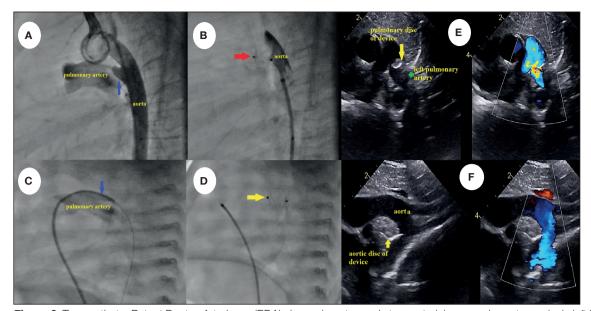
Transcatheter Patent Ductus Arteriosus (PDA) closure by retrograde transarterial approach; aortography in left lateral view shows conical type (Type-A) of PDA (A). Aortography in the left lateral view shows the implanted Amplatzer Piccolo Occluder 4/4 mm which is in the proper position within the duct and extraductal disc placement with no residual shunt and no protrusion into the aorta (B). Transcatheter PDA closure by anterograde transvenous approach and only by femoral vein access; a straight lateral image; while manually injecting the contrast, the catheter is withdrawn and the central diameter and length of the PDA [fetal type (Type-F)] are determined (C). The left lateral view shows the implanted Amplatzer Piccolo Occluder 5/4 mm in the proper position within the duct and extra ductal disc placement (D). The control echocardiography during the procedure revealed that the device did not protrude into the descending aorta or pulmonary artery (E,F). On all fluoroscopy images, the red arrowhead points to Amplatzer Piccolo Occluder 4/4 device, the yellow arrowhead points to Amplatzer Piccolo Occluder 5/4 mm device, and the blue arrowhead points to PDA.
